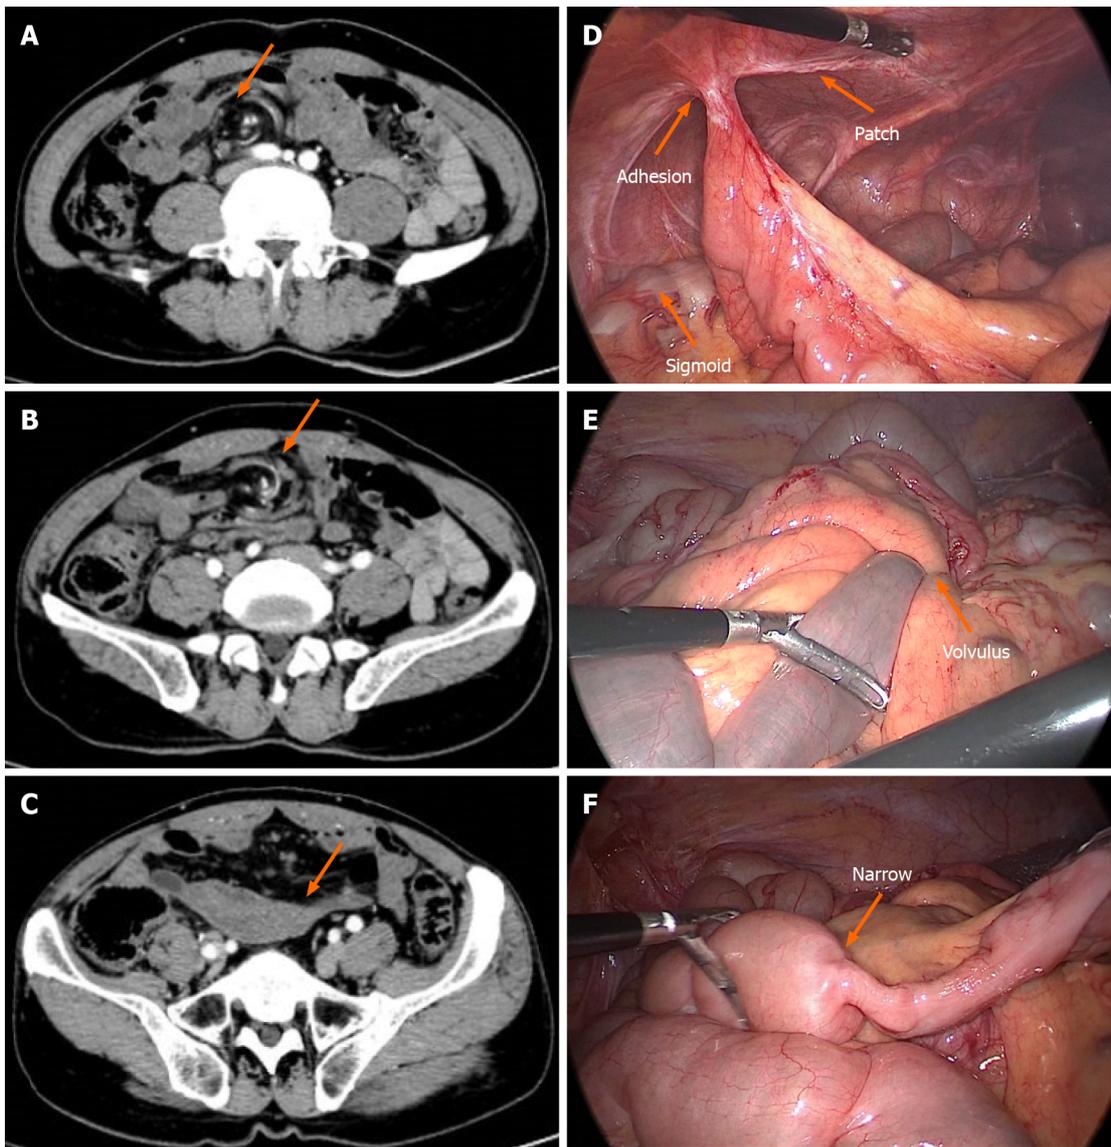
Computer tomography and intraoperative findings. A and B: Computed tomography (CT) reveals the whirlpool sign of the mesentery; C: CT reveals a proximal dilated bowel and distal normal bowel migration; D: Adhesion band on the small bowel; E: Small bowel volvulus; F: Intraoperative exploration found the migration area of proximal dilated bowel and distal normal bowel.
